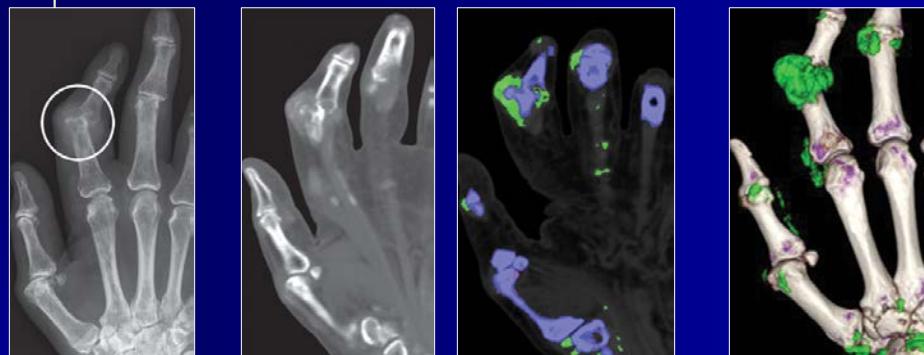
Image from: Desai MA, et al. Clinical Utility of Dual-Energy CT for Evaluation of Tophaceous Gout. Radiographics 2011;31:1365-75
